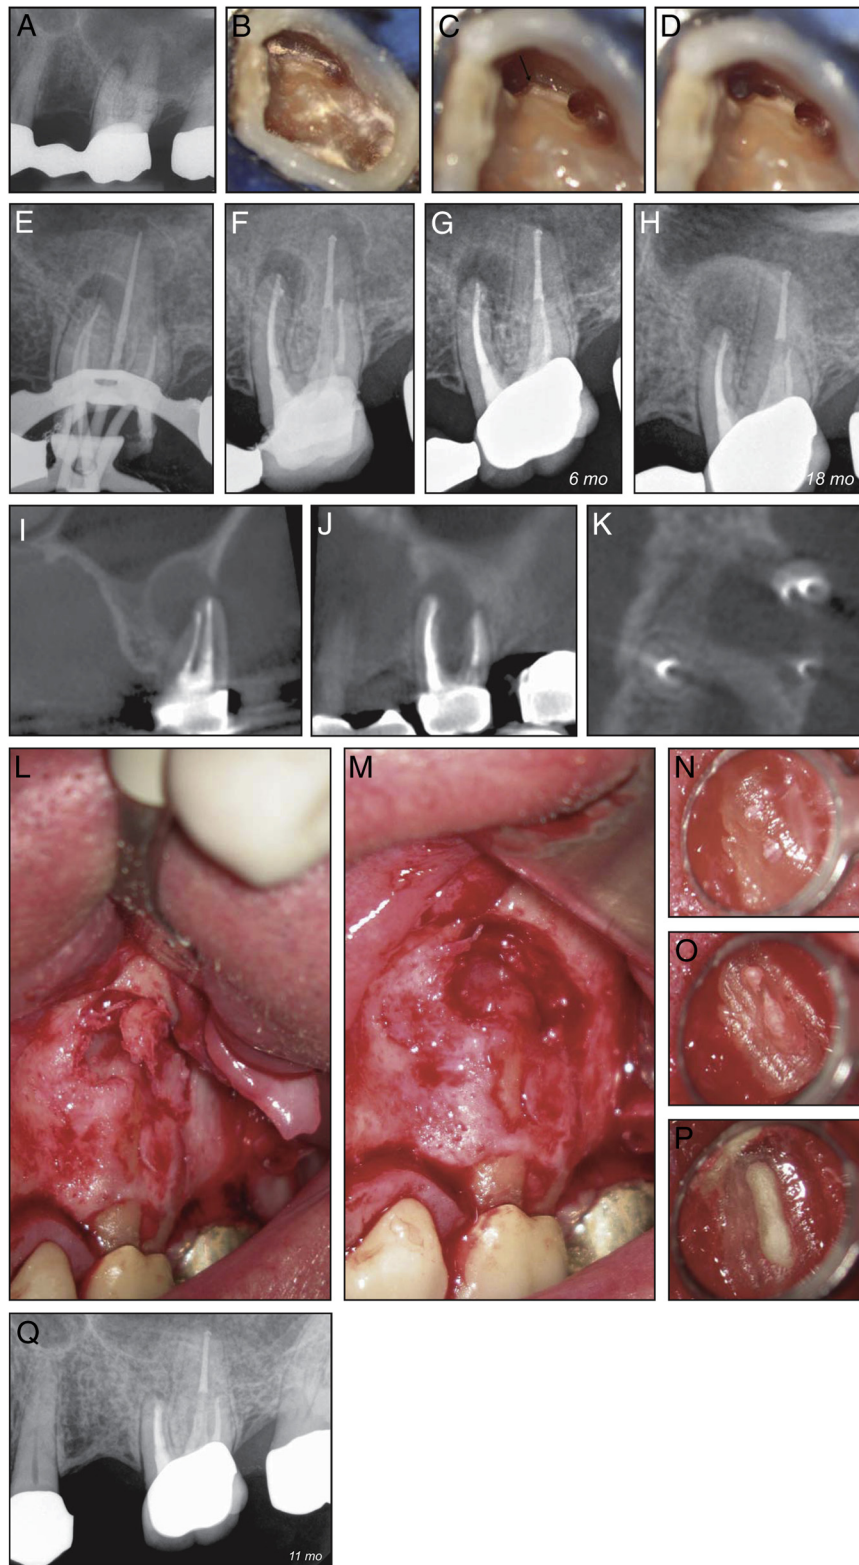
(A) A radiograph of tooth #14 taken during a routine checkup by a general dentist showing periradicular radiolucencies. (B–D) A sequence of photographs showing the negotiation of MB1 and MB2 and the isthmus connecting the 2 canals as performed by an endodontist. (E) Gutta-percha cone selection and (F) postobturation radiograph. (G) A 6-month follow-up radiograph. The radiolucencies on the distobuccal and palatal roots had considerably decreased whereas that on the mesial root remained the same size. (H) An 18-month follow-up radiograph. The lesion on the MB root became larger. Apical surgery was scheduled. (I–K) Cone-beam computed tomographic scans showing the extent of the lesion and its relationship with the maxillary sinus floor. (L and M) After elevating a mucoperiosteal flap, the cortical bone covering the pathologic tissue was carefully mobilized to create an access to the MB periradicular area. (N) The resected root end, (O) the prepared root-end cavity, and (P) filling with MTA. (Q) A follow-up radiograph taken 11 months after surgery.
